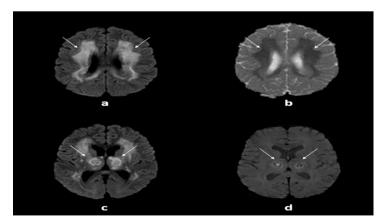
Axial DWI MRI (a, c), ADC (b), and GRE (d) images of the brain demonstrating hyperintense signals on DWI and corresponding areas of reduced ADC suggestive of cytotoxic edema/damage in bilateral periventricular white matter and thalami (white arrows in images a, b, c). Susceptibility effects noted on GRE images suggestive of hemorrhages (white arrows in image d).
